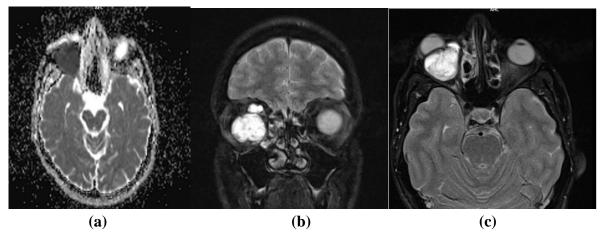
Magnetic Resonance Imaging of the Orbit T2+C; (a+c): coronal; (b): axial
